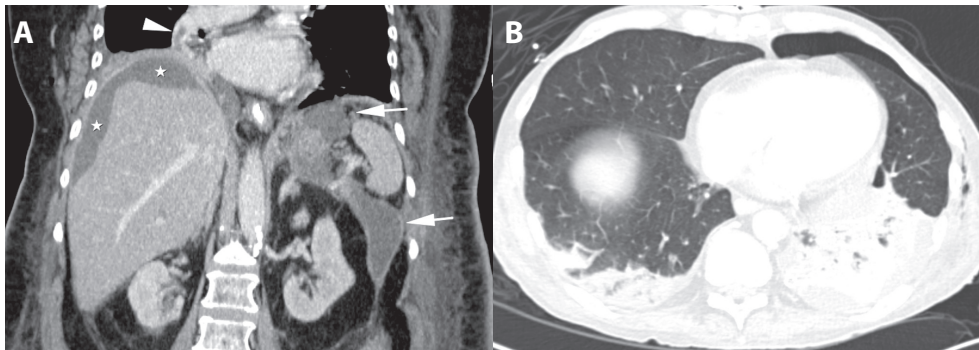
Two different patients (a, b) with pulmonary complications during an episode of acute pancreatitis. (A) Coronal reformatted contrast-enhanced CT in a 69-year-old woman shows signs of acute necrotizing pancreatitis with necrotic collections in the left retroperitoneum (arrows) and perihepatic fluid (white stars). As incidental finding, a thrombus was noted in the right pulmonary artery (arrowhead). (B) CT at the lung bases in an 80-year-old man with acute pancreatitis, who experienced a sudden onset of dyspnea and fever, demonstrates a left-sided pneumothorax and bilateral consolidations in the lower lobes, indicative for pneumonia.
